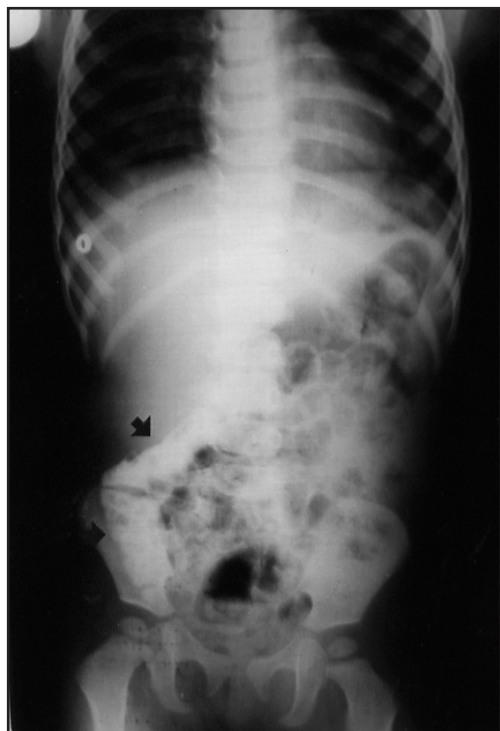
Abdominal radiography shows widespread radio-opaque appearance (iron deposits) in intestines (see arrows)
